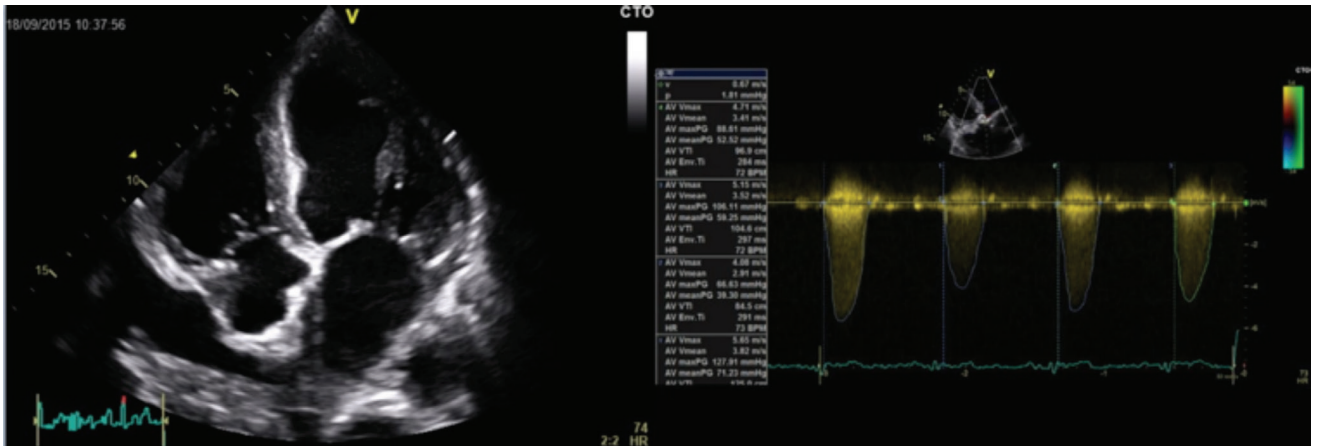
Apical 4-chamber view and continuous Doppler over aortic valve before interventions.
